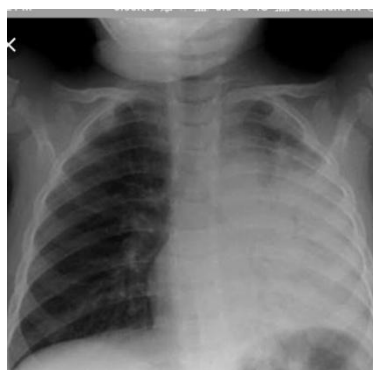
Xray chest P/A view showing left middle and lower lobe atelectasis due to impacted groundnut in the left bronchus.
